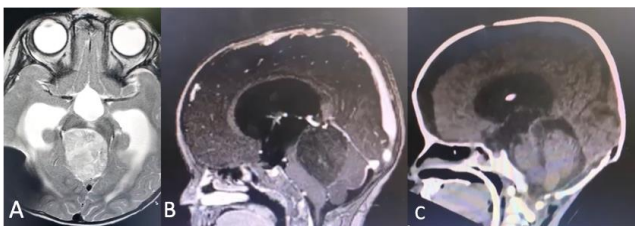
Post-endoscopy MRI. A) Axial T2-weighted image showing a heterogenic lesion in the topography of quadrigeminal cistern. B) Sagittal T1 contrast-enhanced image showing that the mass does not enhance with contrast. C) Post-operative sagittal CT-scan showing total resection after occipital transtentorial approach
